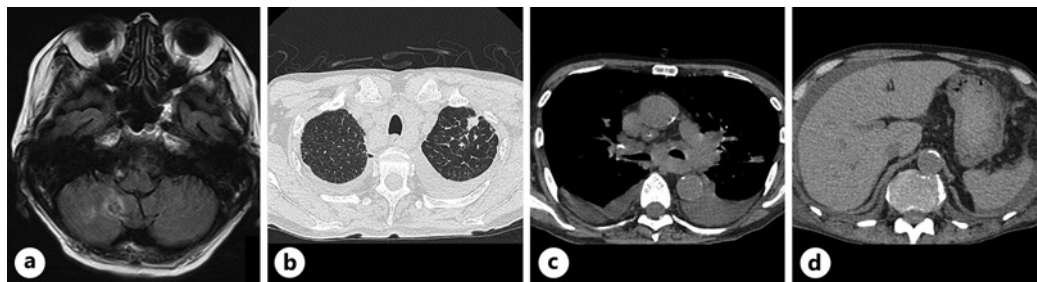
a Magnetic resonance imaging showed brain metastasis. Chest and abdominal CT showed increased size of the nodule in the upper lobe of the left lung (b), bilateral pleural effusion (c), and ascites (d) 15 days after admission. CT, computed tomography.
